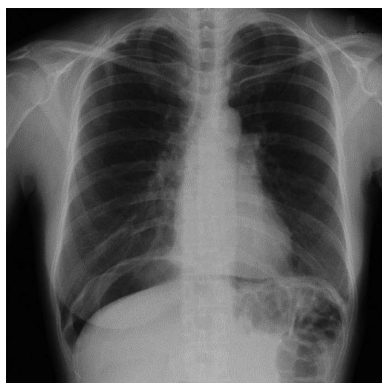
Abdominal radiography 36 h after endoscopic submucosal dissection because of a complaint of severe abdominal pain. A large amount of free air is observed under the diaphragm.
